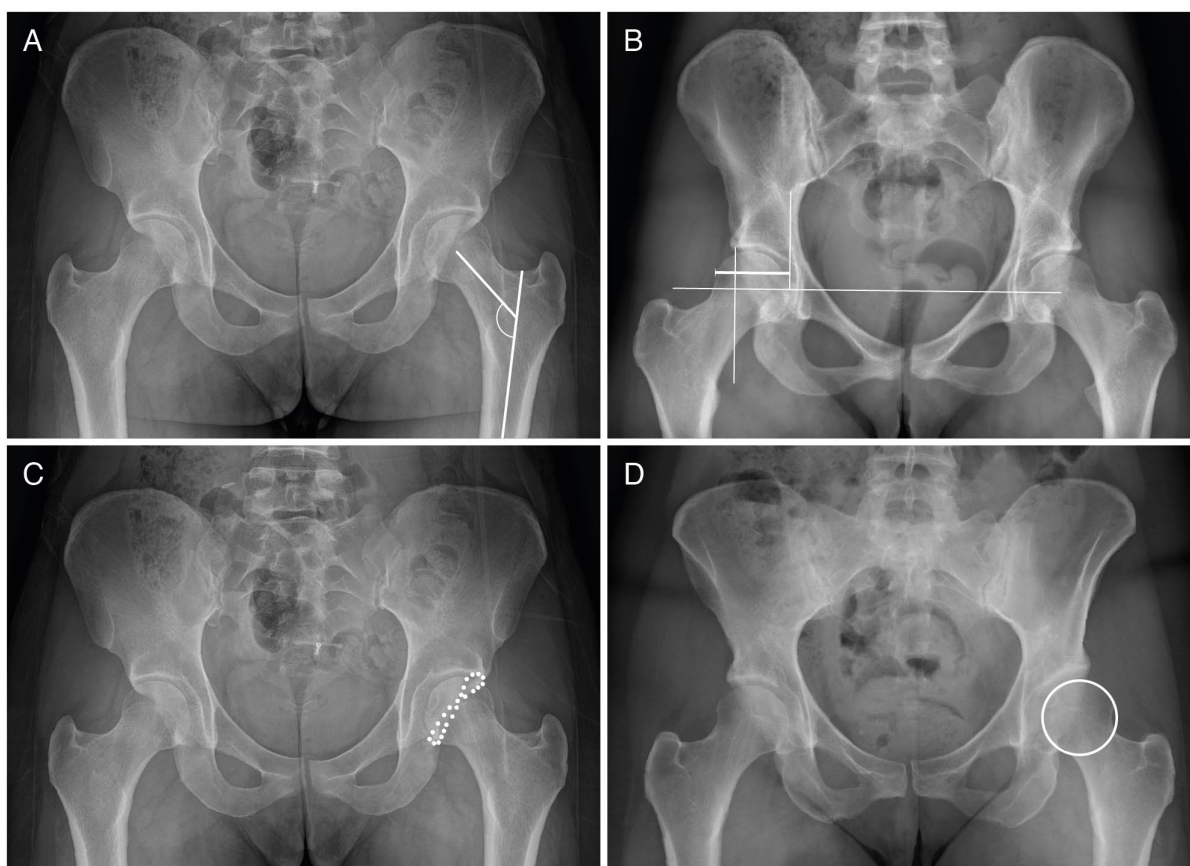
Radiographic presentation of the following four radiographic measurements: (A) Femoral neck-shaft angle, (B) Extrusion index, (C) Cross-over sign, and (D) Cliff sign.
